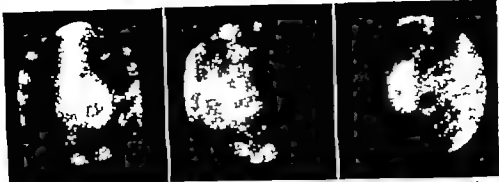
Positive (4+) scintigrams of patient shown in A) anterior B) 45° left anterior oblique C) left lateral views with extensive acute anterior wall infarction.
